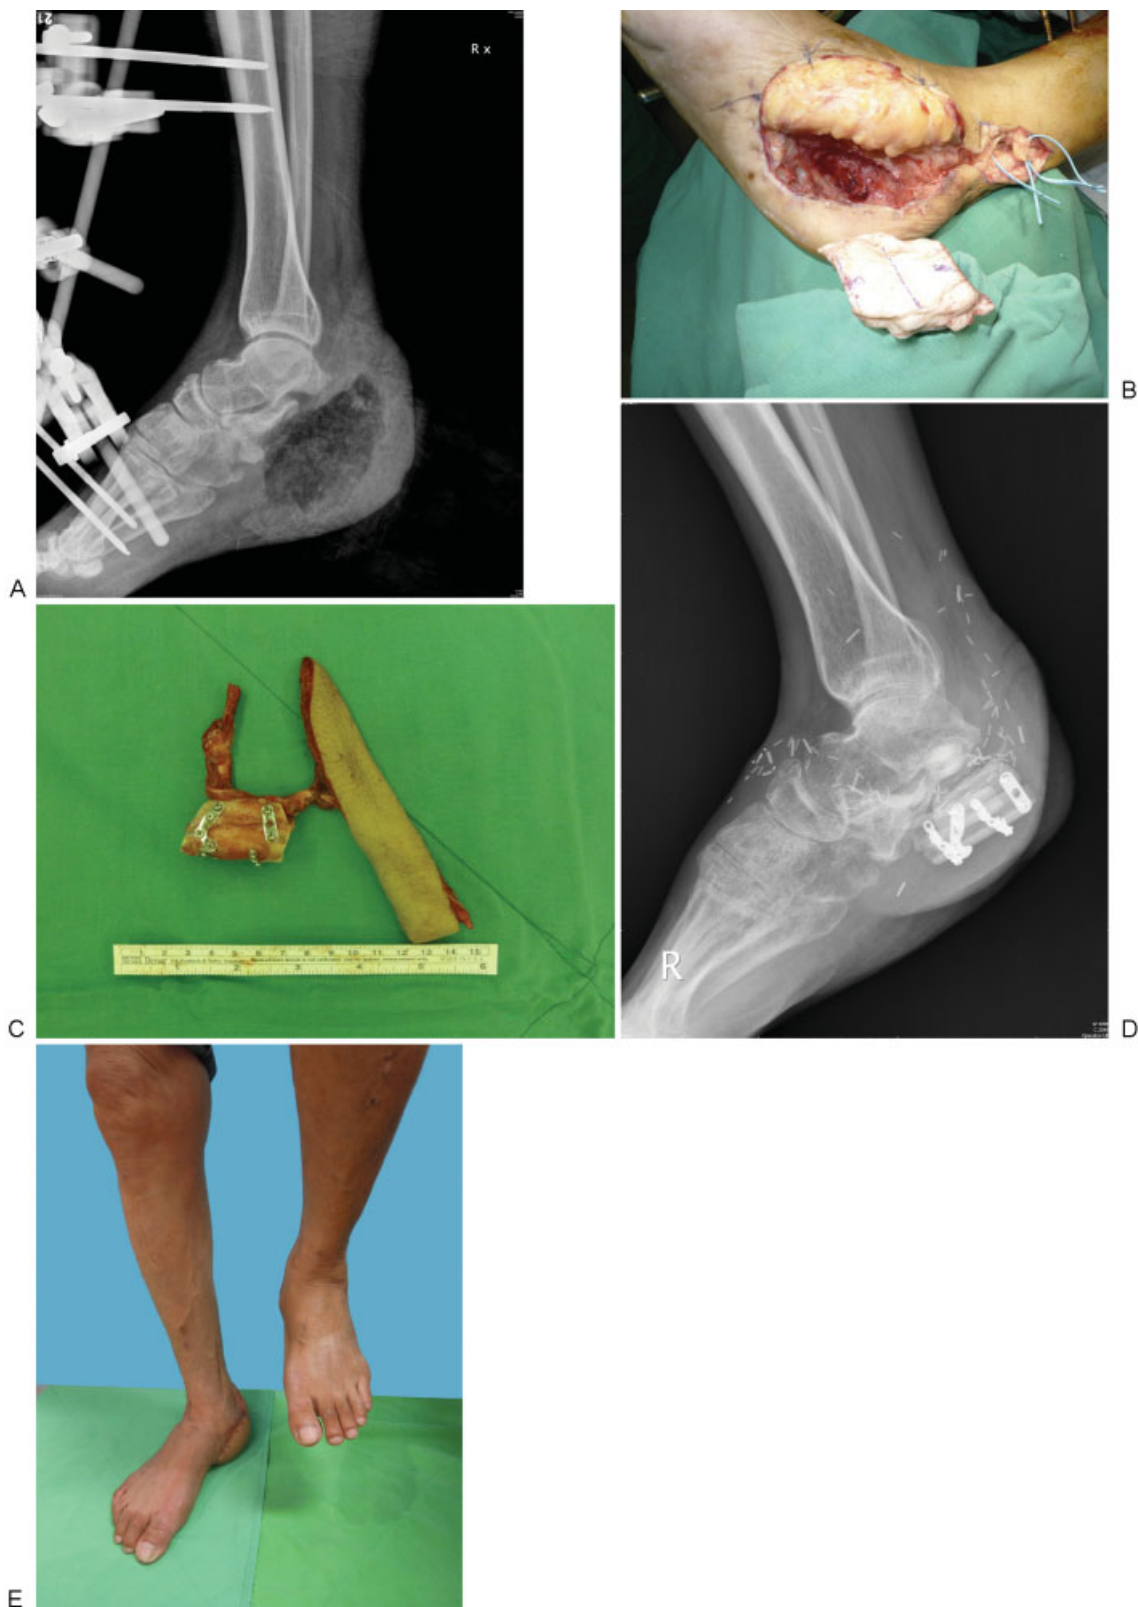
(A) Case 20. A 50-year-old man presented with an open wound over the medial aspect of the right heel and open calcaneal fracture secondary to a fall from height. X-ray revealed an extensive calcaneal defect due to osteomyelitis. After serial debridement, the skin defect measured 14×8 cm with total calcaneal loss. A 12×6 -cm ALT flap was elevated for first-stage soft tissue coverage, and antibiotic beads were deployed to fill the bony defect. (B) The second-stage reconstruction was performed 45 days later. The calcaneal defect was preshaped with bone cement as a three-dimensional template. (C) Double-barrelled fibula osteocutaneous flap with a third barrel of free bone graft was modeled to match the size and shape of the template and inserted in situ using Kirschner wires for complete calcaneal reconstruction. (D, E) At 32 weeks, postoperative X-ray showed bony union and full-weight bearing was regained. (See ▶Video 1, which demonstrates the patient walking with normal gait.)
